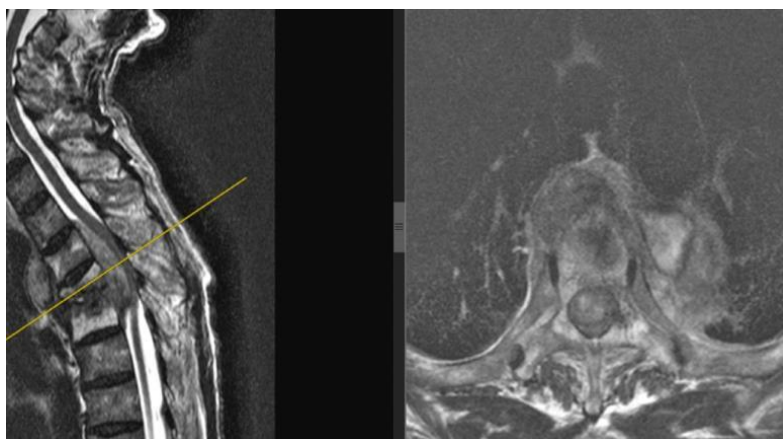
MRI revealed spondylodiscitis Th3-Th4 with extensive epidural abscess and severe spinal cord compression
